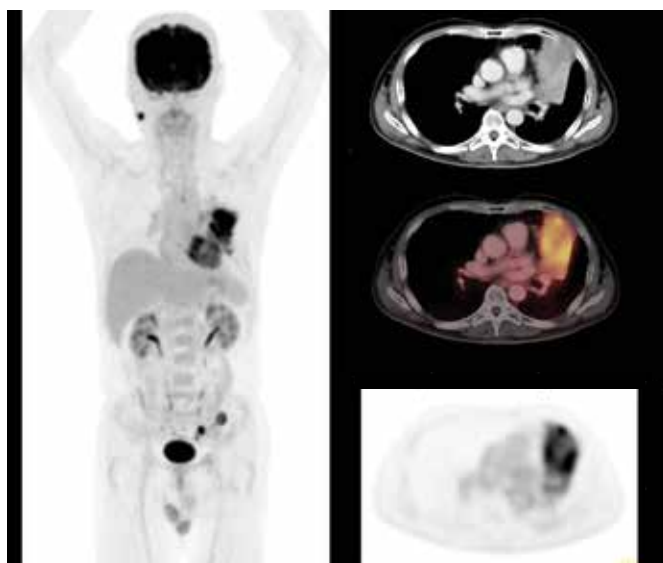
Post-radiation therapy PET/CT shows extensive inflammatory changes in the lung tumor bed in the left hilar region extending to the periphery anteriorly, which is typical of inflammatory infiltrate involving the affected lung lobe in the radiation field. No mediastinal or distal metastatic lesions are visible.
